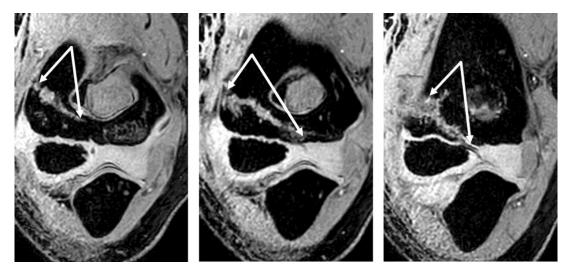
MRI showing LHCF. Left: Stage 1, confined to metaphysis. Center: Stage 2, fracture line stops in the chondroepiphysis. Right: Stage 3, traverses the joint cartilage.
